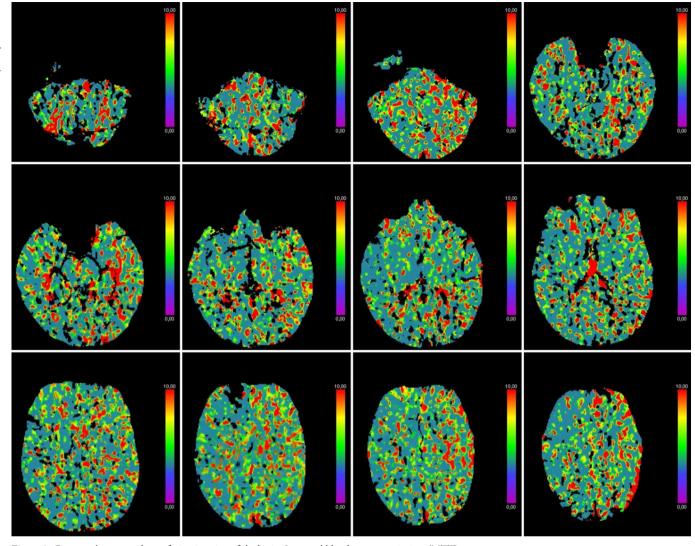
Computed tomography perfusion imaging of the brain: Increased blood mean transit time (MTT).
